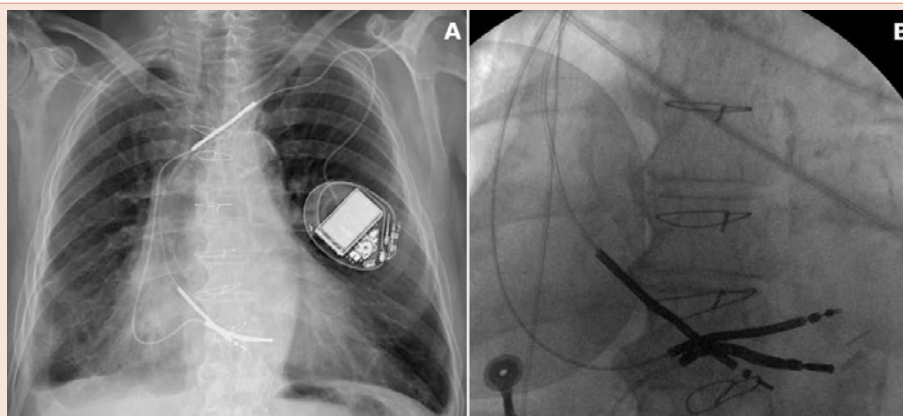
Panel A: chest X-ray at admission, showing the abandoned dual coil lead and the malfunctioning single-coil ICD lead. Panel B: the new active fixation ICD lead is implanted.
